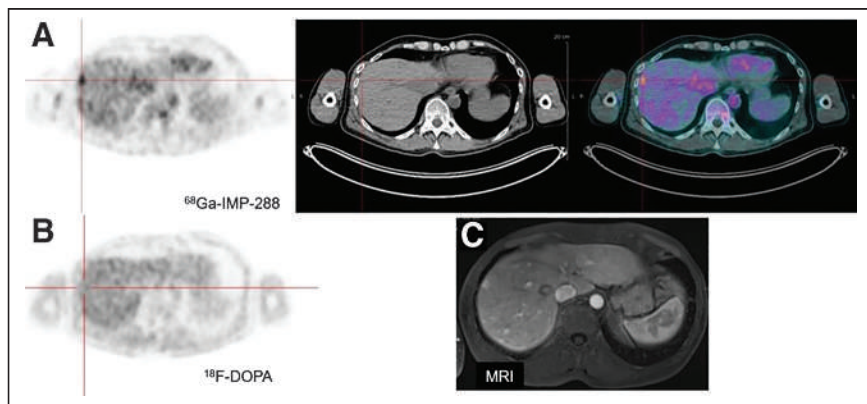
(A) Immuno-PET/CT with anti-CEA BsmAb and ^{68}Ga -IMP288 axial PET, CT, and fusion images showing multiple liver lesions (arrows), whereas ^{18}F -DOPA PET was negative (B). (C) MRI-confirmed lesion.
